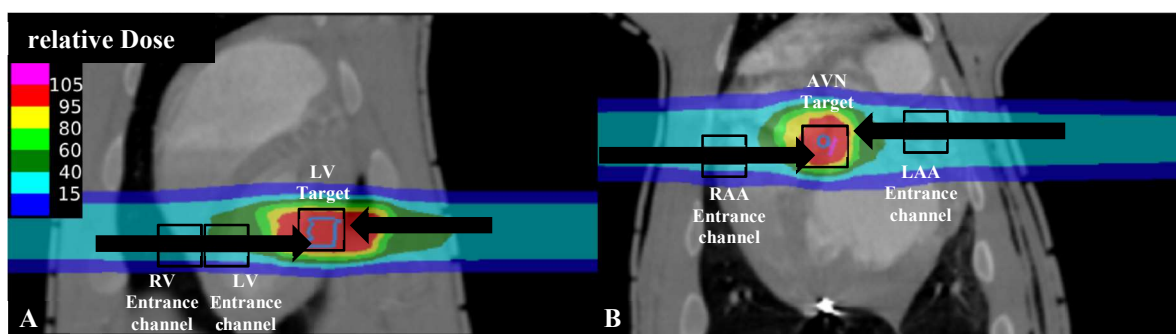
CT scans of the heart with exemplary dosecuts from the coronal (right) view. Targets and entrance channel regions are indicated for the irradiation of the LV (A) and the AVN (B). Regions, where tissue was harvested for analyses, are highlighted with boxes. Modified after (Eichhorn, 2016).
